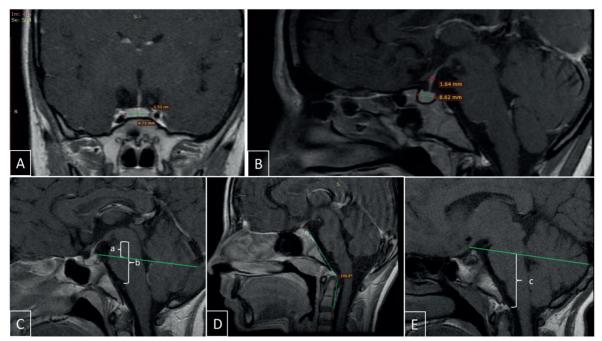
Measurement methods used in the study. (A) Pituitary height and width measurements from coronal postcontrast T1-weighted images at the widest points of the pituitary gland. (B) Mid-sagittal T1-weighted image presents the anteroposterior diameter of the pituitary gland and the thickness of the stalk. (C) Mid-sagittal T1-weighted image demonstrates the pons ratio (a/b). (D) Mid-sagittal T1-weighted image represents measurement of the clivus canal angle, the angle between the dorsal surface of the clivus and the posterior margin of the odontoid process of the C2 vertebra. (E) Mid-sagittal T1-weighted image demonstrates the Klaus index (c) between the tip of the odontoid process and the line connecting the tuberculum sella and internal occipital protuberance.
